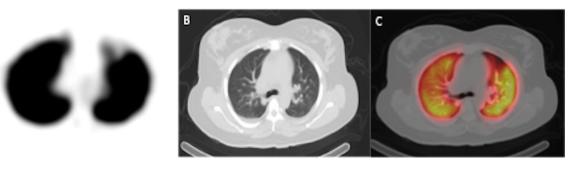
64-year-old woman with laboratory diagnosis of COVID-19 presenting with pleuritic left-sided chest pain. Axial perfusion (Q)-only SPECT image (A) demonstrating wedge-shaped defects in the left upper lobe without corresponding parenchymal abnormalities on axial CT chest (B). Fused axial Q-SPECT/CT showing wedge-shaped perfusion defect in the left upper lobe, suspicious for pulmonary embolus.
